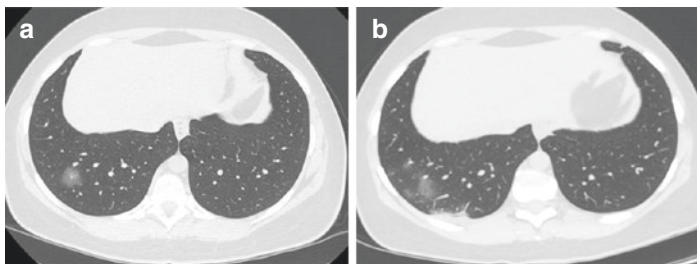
HRCT. (a) Monolateral focal rounded GGO with vessel enlargement in a 33-year-old woman, mild symptomatic, with professional exposure. Three subsequent nasopharyngeal swabs negative. (b) HRCT 1 week after: monolateral multifocal GGO and pleural reaction; RT-PCR turned positive
